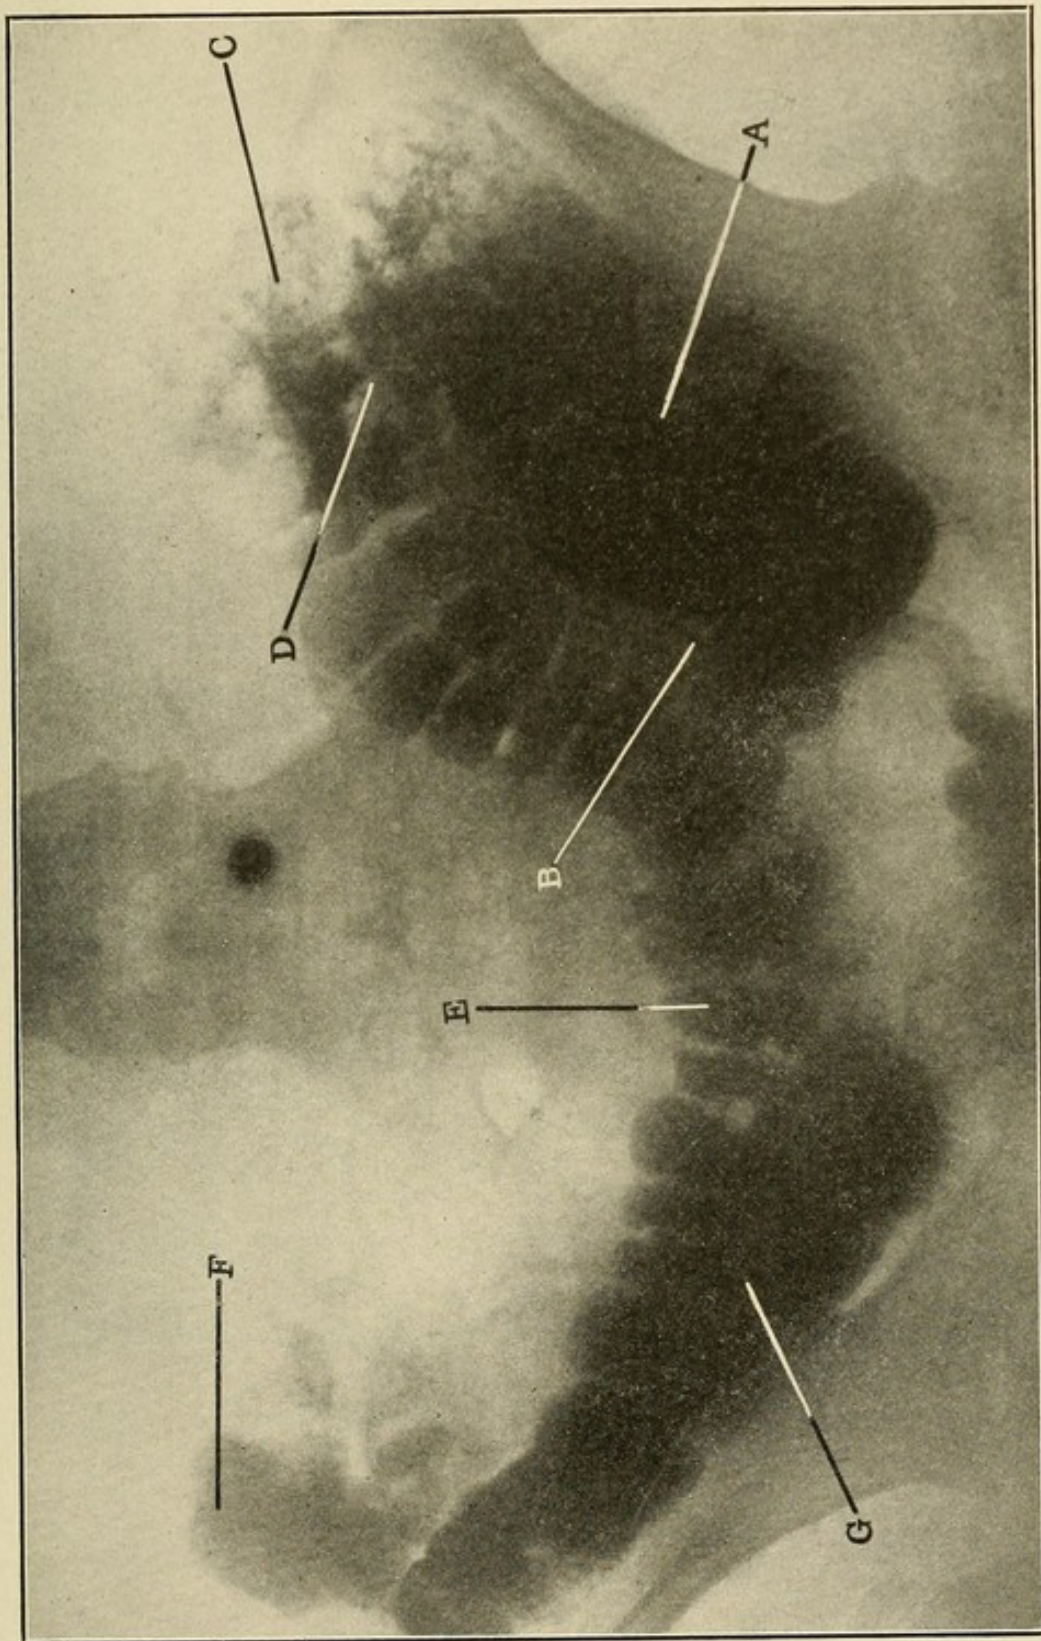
Coloptosis (complete). (*Made in the X-ray laboratory of Dr. Anthony Bassler, New York City.*)
